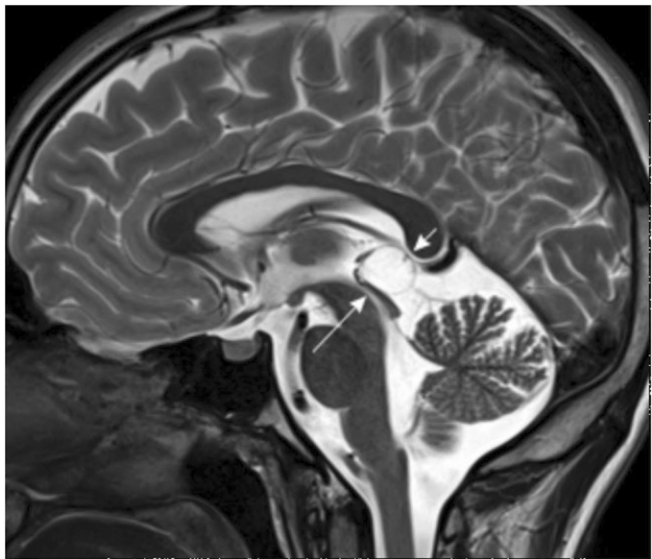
Cystic formation of the pinealis gland (in an 18-yr-old male applicant). A sagittal T2-weighted image in the median plane. The pinealis gland can be defined as a round, thin-walled cyst (short arrow). The adjacent structures, such as the superior colliculi of the tectum, are initially compressed. However, the cerebral aqueduct is not yet affected (large arrow).
